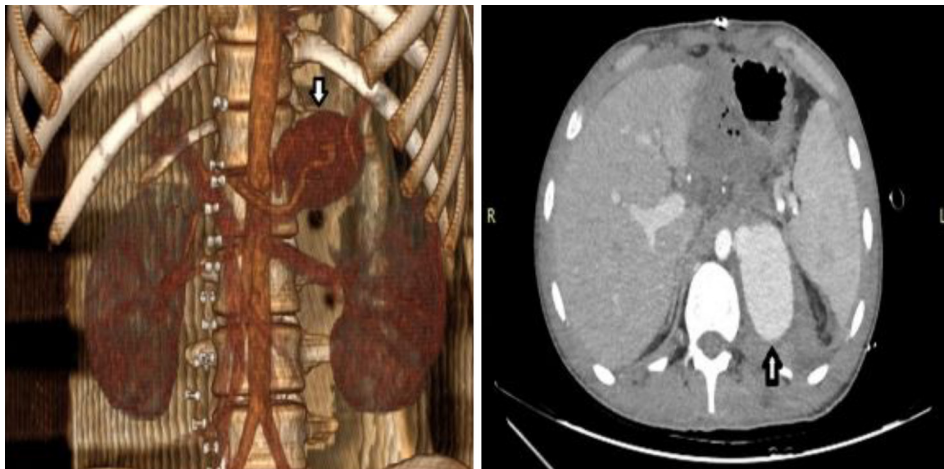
Preoperative computed tomography angiography images of traumatic abdominal aortic pseudoaneurysm at the level of celiac trunk. Tip of the white arrow shows aortic pseudoaneurysm.
